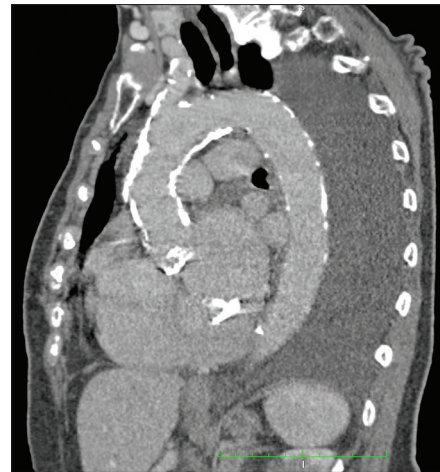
The preoperative computed tomography showing the extremely calcified aorta and the aortic valve
